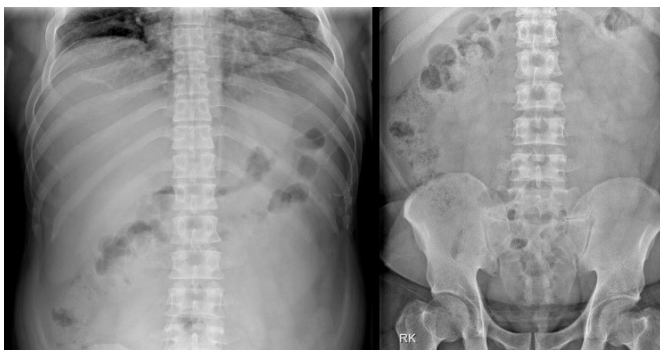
Abdominal/pelvic x-ray shows no specific findings suggestive of acute gastroenteritis or ureter stone.
